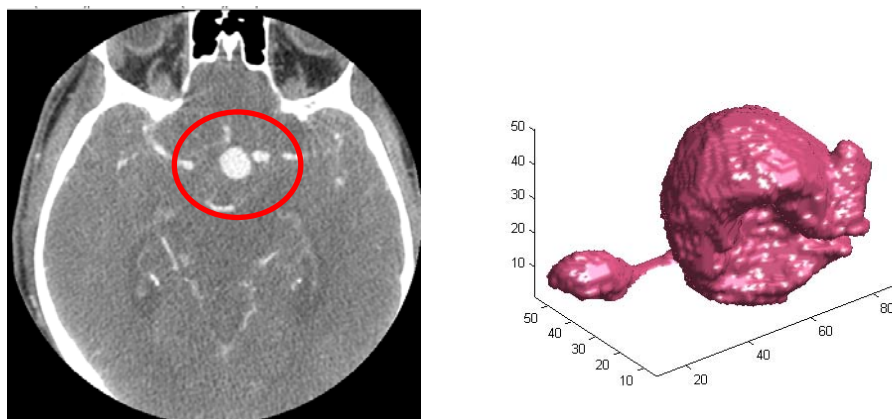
Left, a slice of interest in the CTA series and Right, the segmented aneurysm.
